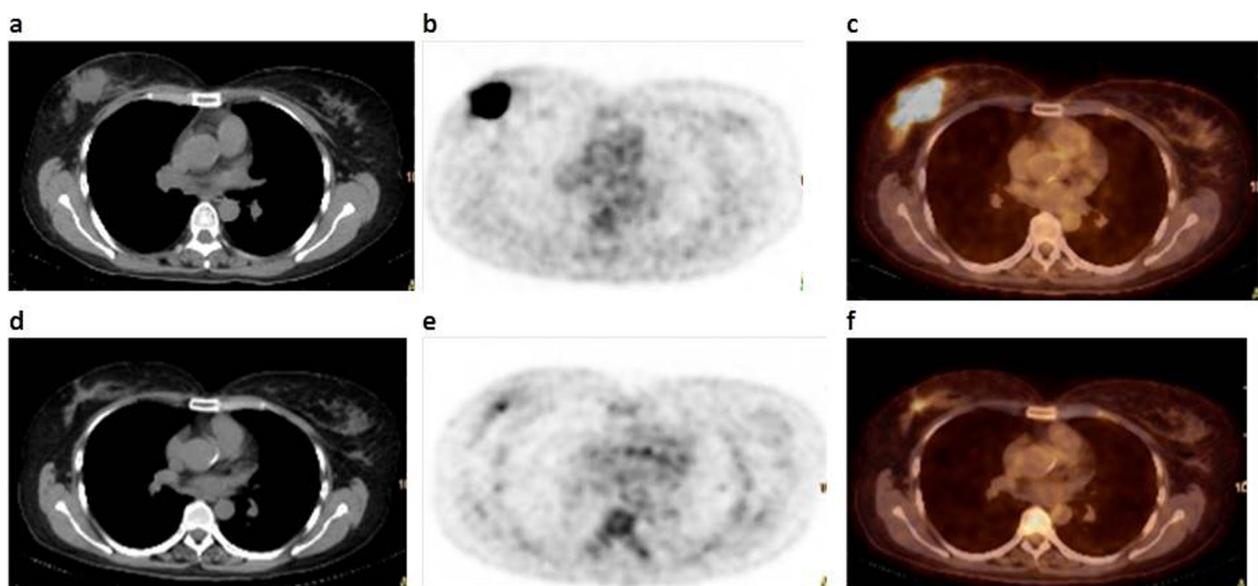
48 years old female patient presented with clinically palpable right breast mass biopsy revealed IDC grade III. a Axial CECT image revealed right breast speculated soft tissue mass lesion measuring about 55 × 60 mm that was eliciting dense tracer fixation reaching 13.5 SUL_{peak} in axial PET (b) and fused PET/CT (c) images. On follow-up after completion of chemotherapy, marked morphologic and metabolic regression of the mass was noted in the form of reduction in size (reaching 10 × 12 mm) in axial CECT image (d) denoting partial response and reduction in SUL_{peak} (reaching 2.7) in axial PET (e) and fused PET/CT (f) images denoting partial metabolic response
